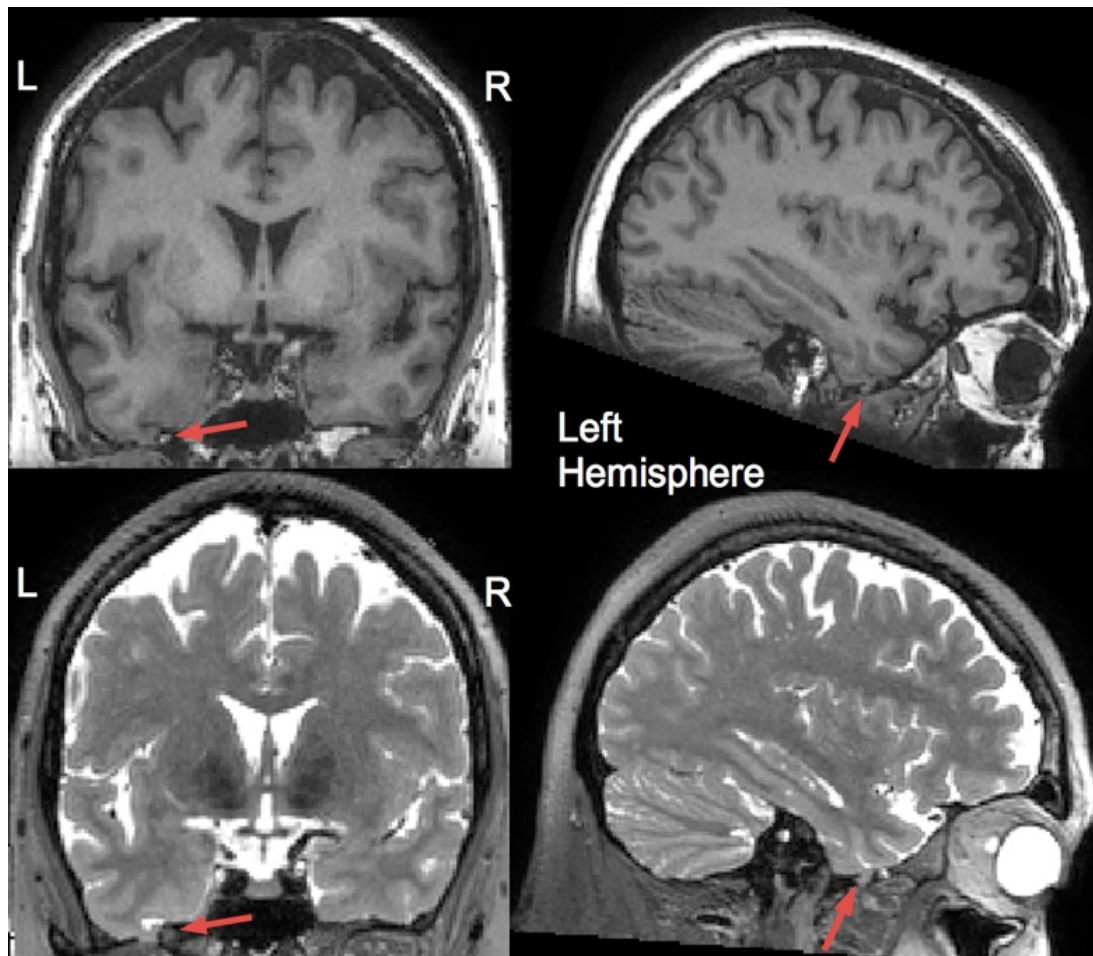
Patient 61: left temporal encephalocele. Left temporal encephalocele was diagnosed based on a 3D volume T2w acquisition, which is not routinely acquired in the evaluation of patients with epilepsy at the WCFT but was part of the study's dedicated epilepsy research protocol. Note how the lesion is more conspicuous on the T2w image (below) compared to the T1w (top). Diagnosis was later confirmed with computed tomography imaging. Older MRIs (all 2D) with large slice thickness (~5 mm) from 2009 failed to reveal this abnormality. L = left; R = right.
